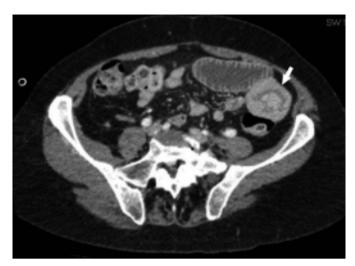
Pre-operative CT scan which shows intussusception with a typical cockade appearence (arrow).
